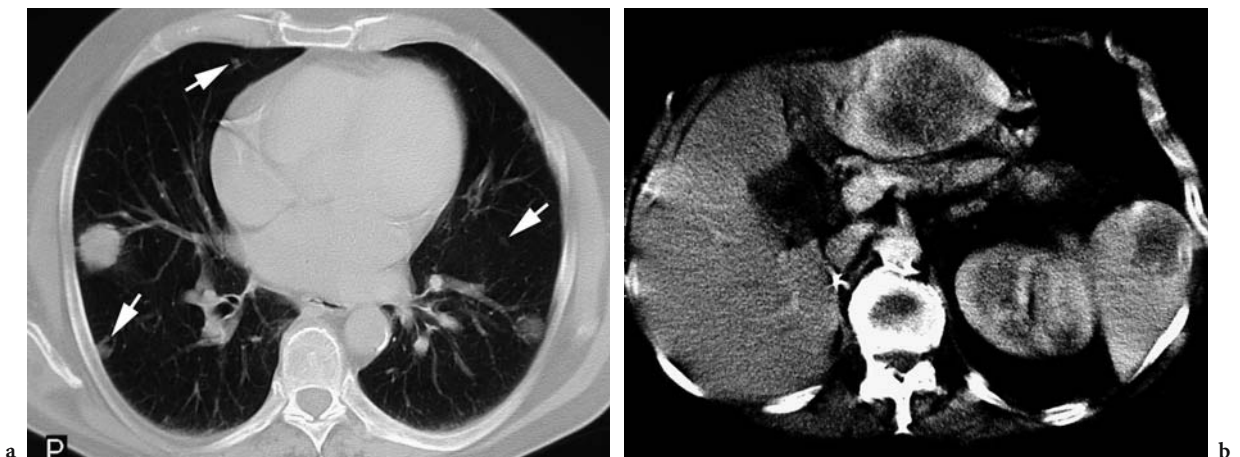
Lung, liver, and spleen metastases in a 66-year-old man who underwent right nephrectomy for renal cell carcinoma. a Axial CT scan shows bilateral rounded pulmonary nodules of different sizes. The small peripheral nodules (*arrows*) were not seen on a conventional radiograph. b Axial contrast-enhanced CT scan of the abdomen shows large lesions in left hepatic lobe and spleen with peripheral enhancement and central necrosis.
